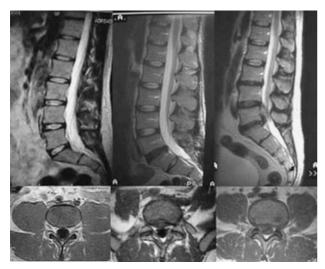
Degrees of discopathy. T2-weighted magnetic resonance imaging with sagittal and coronary planes in three patients. Left-hand column: normal discs. Central column: bulging (symmetrical enlargement, over 50% of the disc, not deemed pathological). Right-hand column: true disc protrusion with compression of the dural sac.
